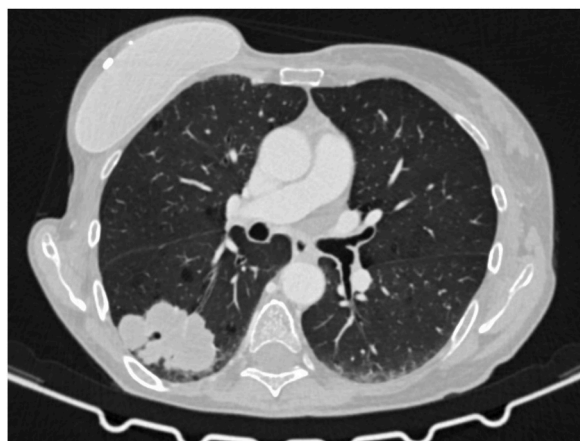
An initial CT scan revealed a solid pulmonary nodule in the right lower lobe with signs of bilateral emphysema.
